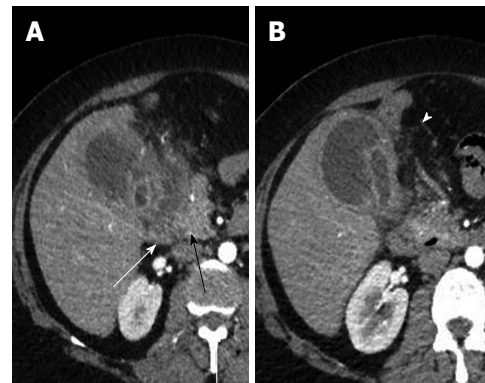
Axial arterial phase computed tomography image showing an area of hyper perfusion in the segment V of liver adjoining a gallbladder showing diffusely thickened walls. Also noted is the blurring of interfaces between gallbladder wall and adjoining liver parenchyma. Liver infiltration can demonstrate an early enhancement of the parenchyma which pathologically corresponds with accumulation of inflammatory cells and abundant fibrosis.
